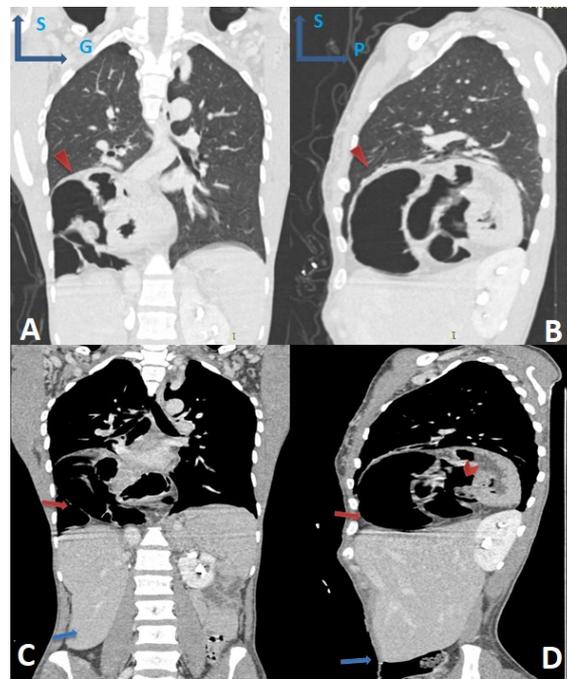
Thoracic-abdominal CT after contrast injection. Coronal (a and c) and sagittal (b and d) reconstructions showing the stomach (arrow head) and part of the colon (pink arrow) above the liver (blue arrow) and bounded at the top by the right diaphragm dome (pink triangle) which is dilated and keeps its integrity.
